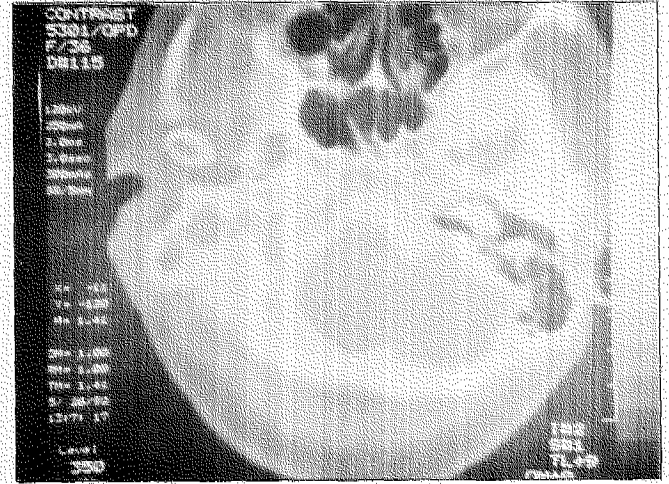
CT scan film showing soft tissue bony destruction of (R) mastoid area consistent with cholesteatoma.
